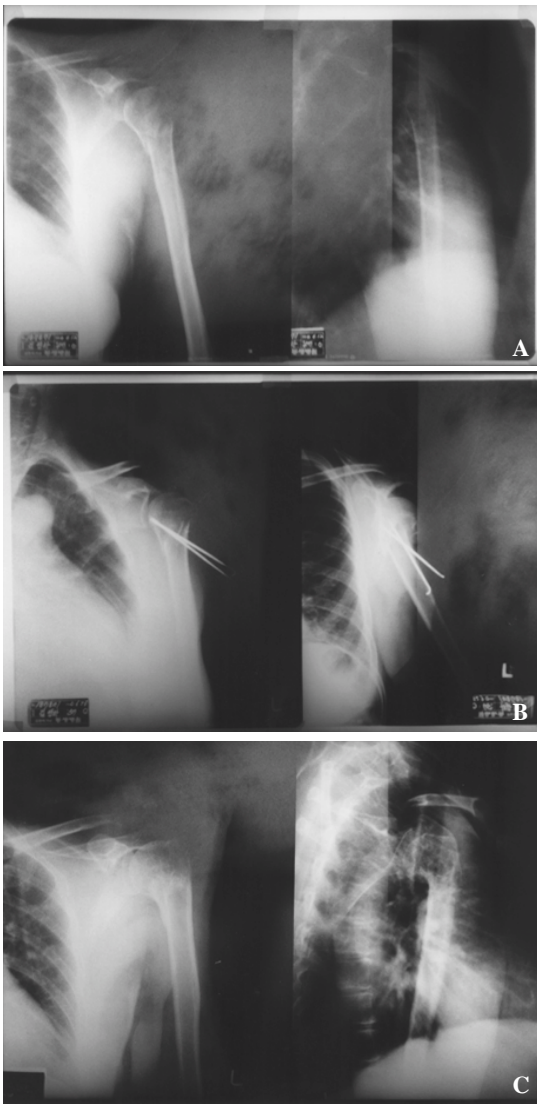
The preoperative radiograph of 56-year-old woman shows fracture of the proximal humerus.
